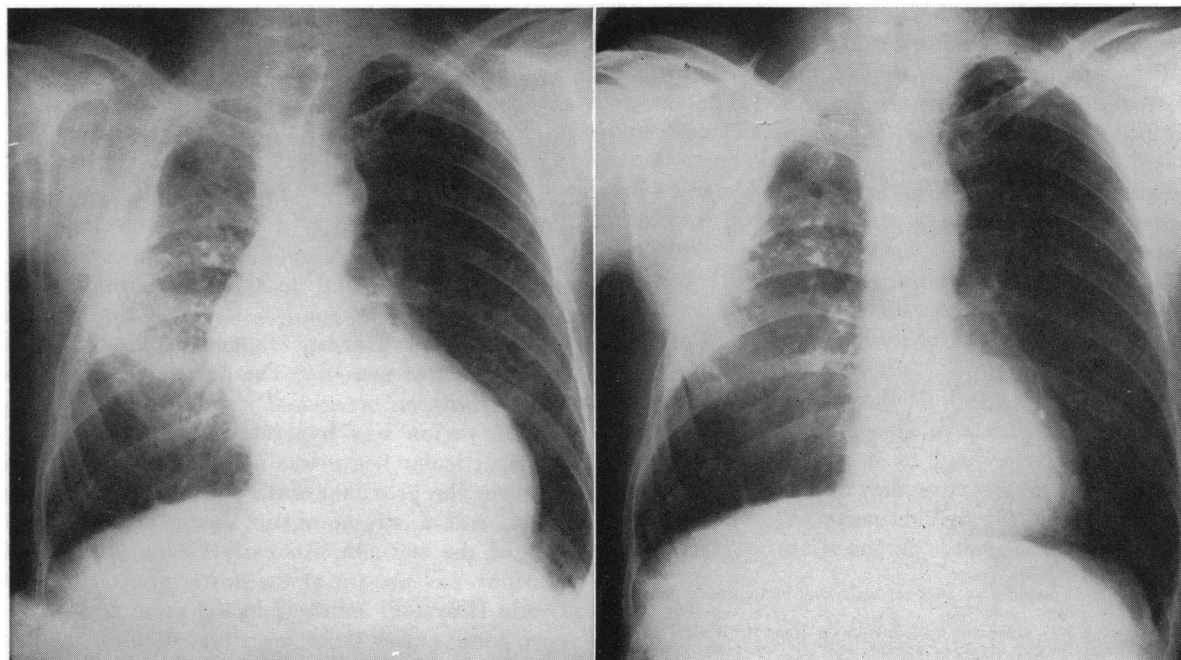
Preoperative and postoperative x-ray films of the chest. The pulmonary changes are the result of old tuberculosis.
